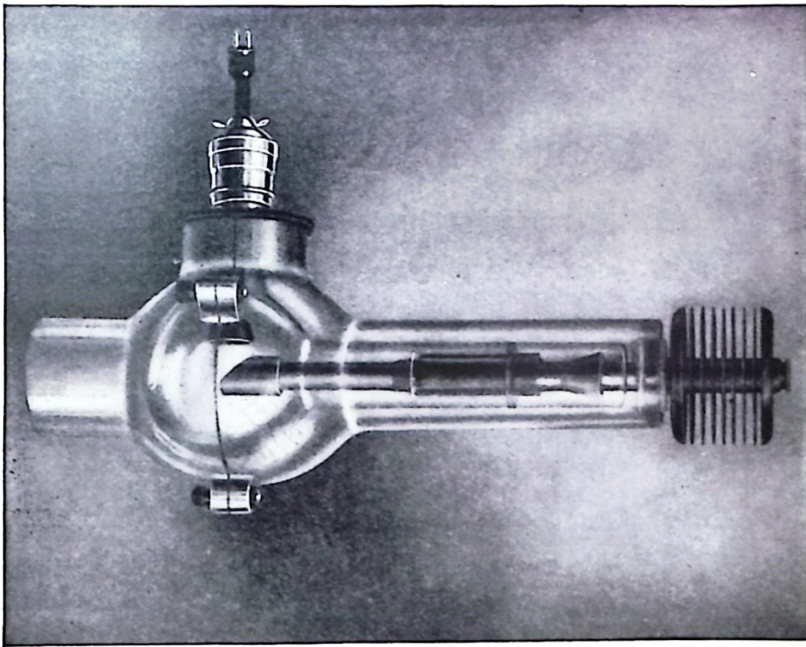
Radiator Dental Type Coolidge X-Ray Tube Enclosed in Lead Glass Protective Shield
